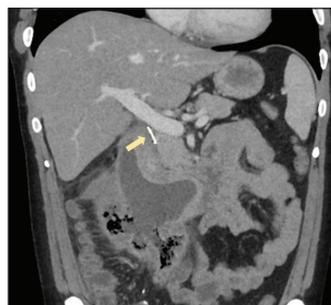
Coronal CT, 1 week after showing liquefaction of the hematoma and contained duodenal perforation. Note the good radiopacity of the plug without streak artifact (yellow arrow).
